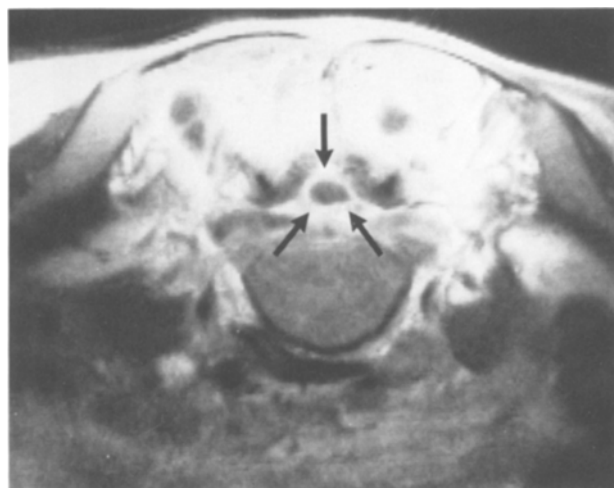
MRI examination of the same patient as in Fig. 4, transverse view, (T1-weighted, contrast-enhanced) presenting a high signal intensity around the membranes of the dura (arrows). The intradural space occupying pus remains of low signal intensity
